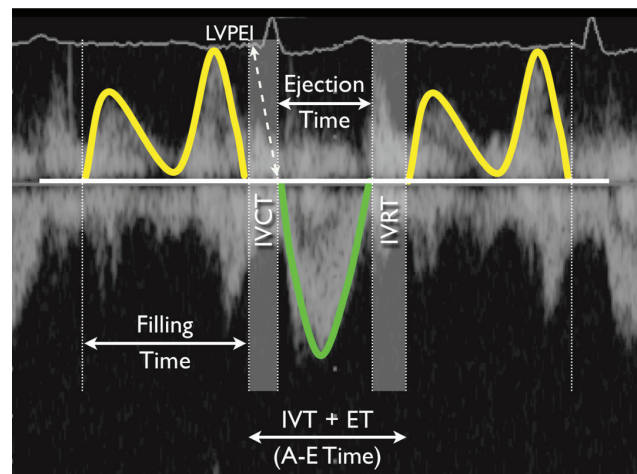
Pulsed wave Doppler indices of LV function and dyssynchrony. LV pre-ejection interval (LVPEI)—time from the onset of QRS to the onset of ejection. IVCT = isovolumic contraction time; IVRT = isovolumic relaxation time; Total isovolumic time (t-IVT) = 60 - [(IVCT + IVRT) X Heart rate]; Myocardial Performance Index (MPI) = (IVCT + IVRT)/ejection time, or (A-E Time - ET)/ET. LV = left ventric-le(-ular).
